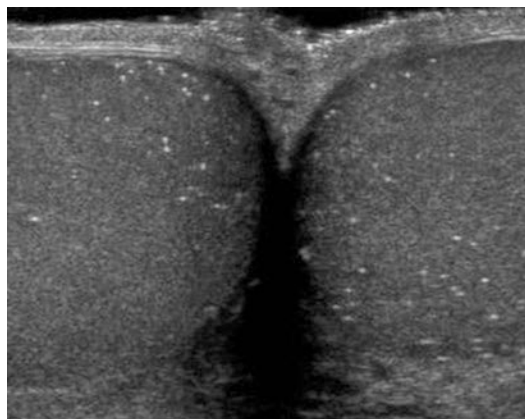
Microlithiasis: transverse sonogram shows multiple diffuse hyperechoic foci with no acoustic shadowing in both testes
